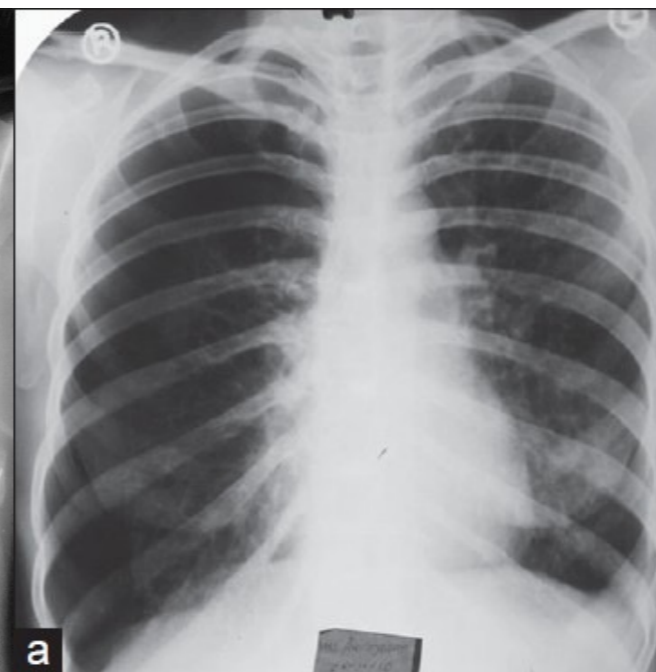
Chest X-ray, pneumothorax.
